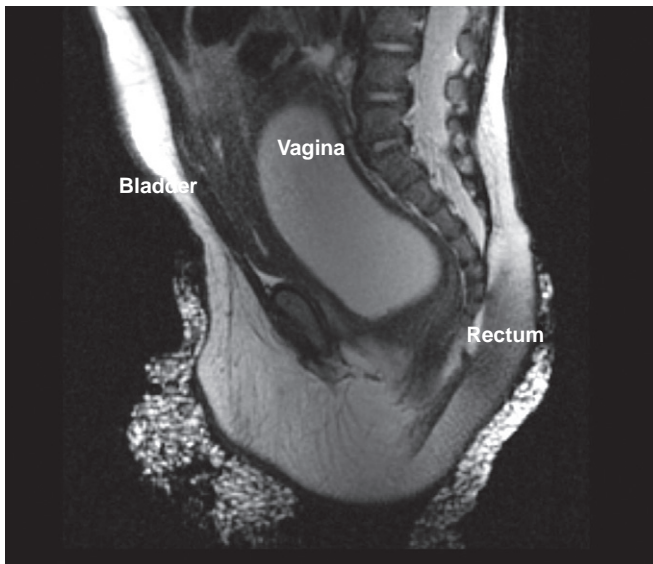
Magnetic resonance imaging of the pelvis in a patient with a posterior cloaca (persistent urogenital sinus and rectovaginal fistula) showing an enlarged vagina, the bladder, and the rectum.
